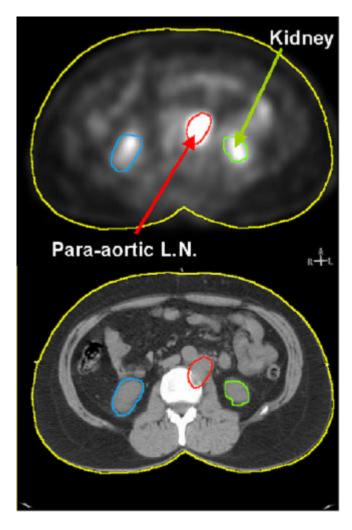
Corresponding PET and CT images with positive PALN.
